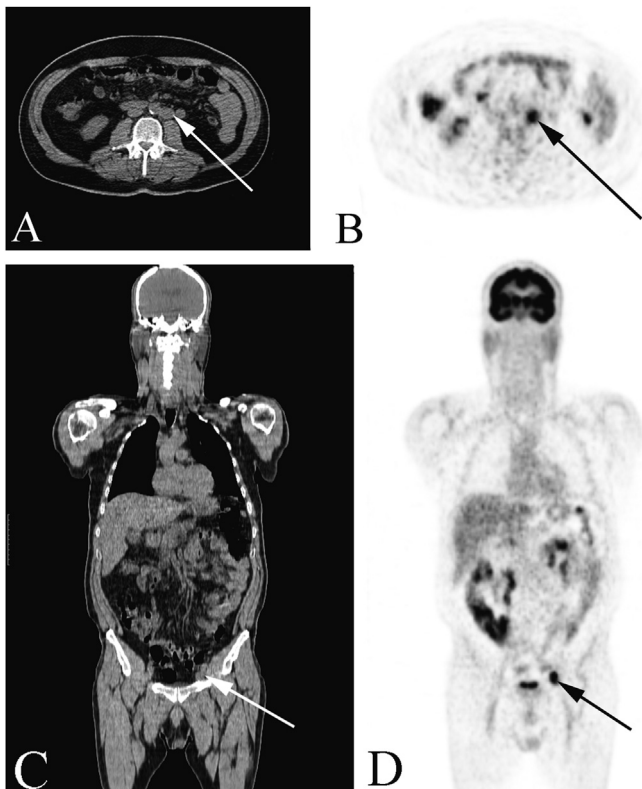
Comparative view of the PET/CT images depicting the two “hot sites” with increased uptake. A. Left paraortic block at the level of the renal vein measuring approximately 26.9 mm (white arrow) and (B) the corresponding view of the PET scan (black arrow). C. Block at the left external iliac vessels measuring 27.2 mm at the level of left internal inguinal ring (white arrow) and (D) the corresponding view of the PET scan (black arrow).
